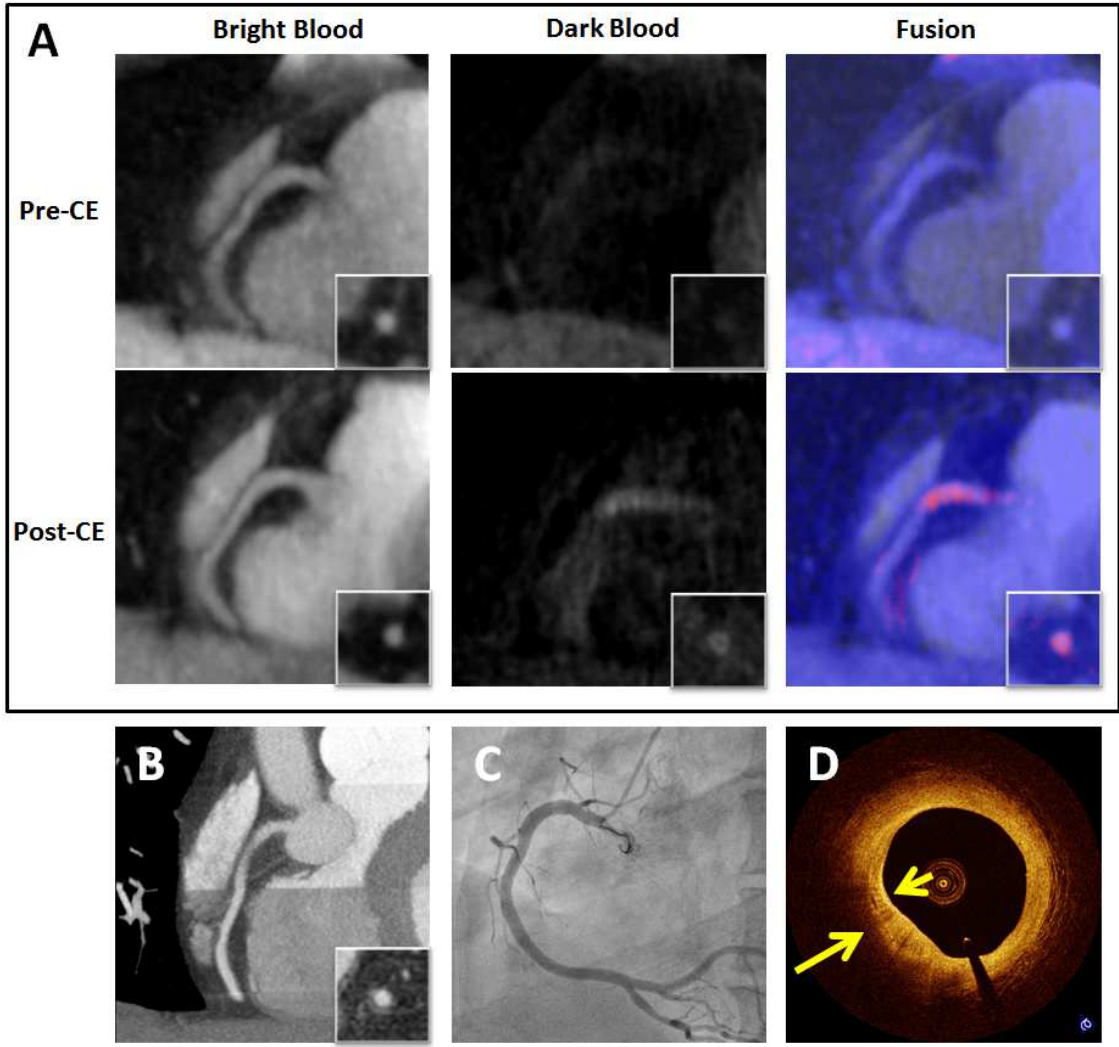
Representative case of a CAD patient with a HIP at proximal RCA on post-CE T1w MRI. A: Pre-CE and post-CE dark-blood T1w images and bright-blood reference images. B: CT angiography. C: X-ray angiography. D: OCT cross-sectional image at the corresponding location of the HIP on MRI.
